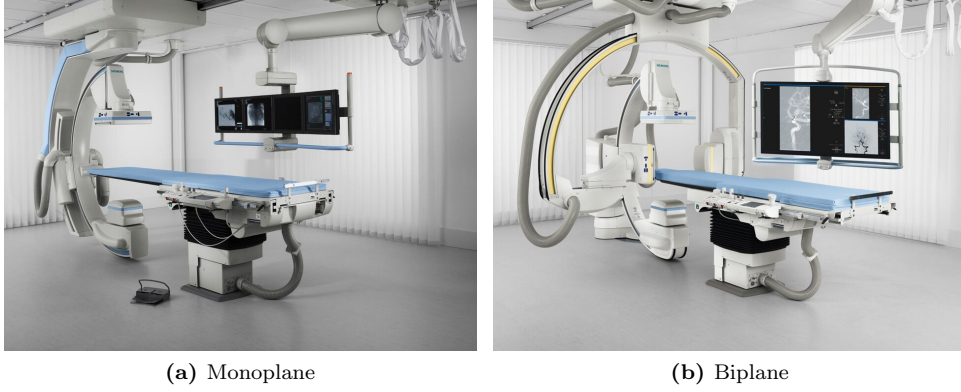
Typical X-ray imaging equipment in a catheterization laboratory in a hospital with a Siemens Artis zee ceiling monoplane system (a) and biplane system (b). (images copyright: Siemens Healthineers AG [3])
